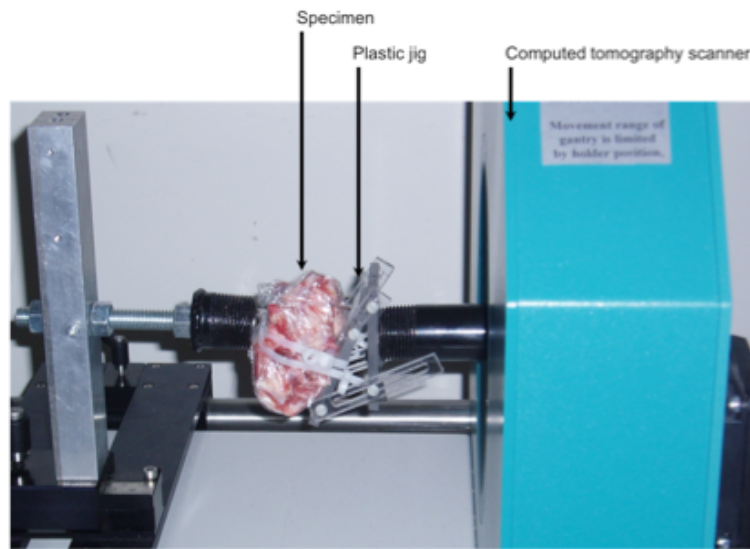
Experimental setup for the computed tomography imaging protocol.
